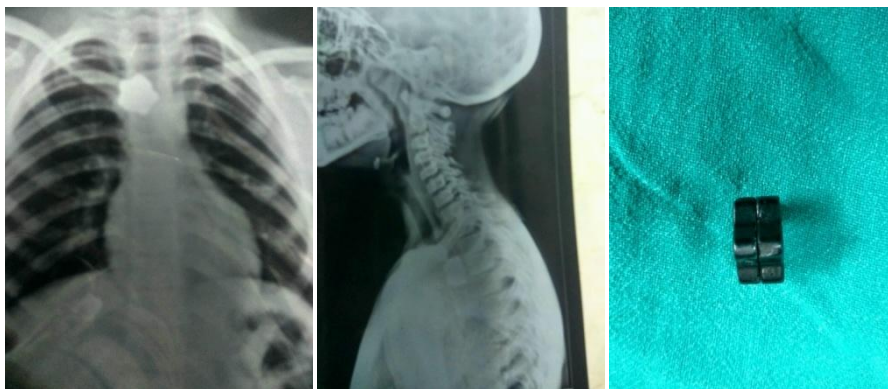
Xray Neck and chest A/P and lateral view showing magnet in upper esophagus along with the removed magnet.
